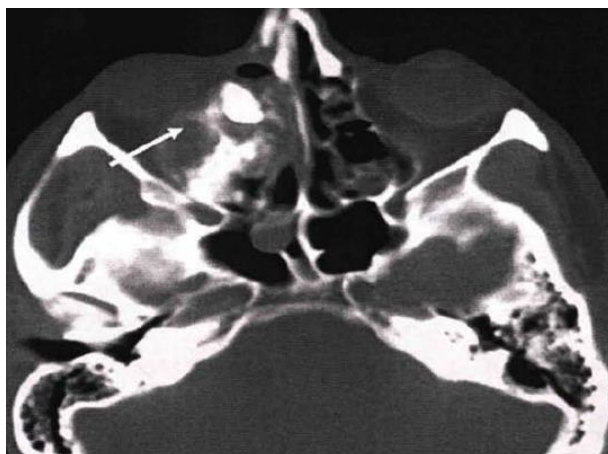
Patient S., 62-year-old, computed tomography scan fragment
